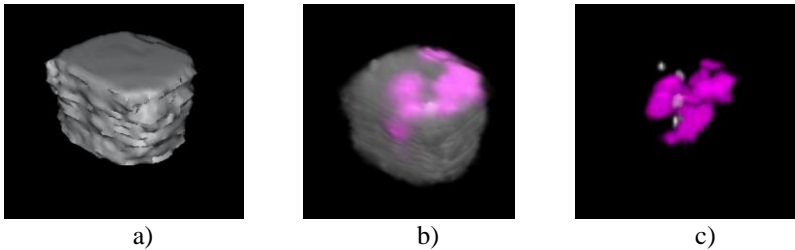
Visualization of the 3D model of the prostate gland, a) volume surface, b) SPECT/CT, c) SPECT
